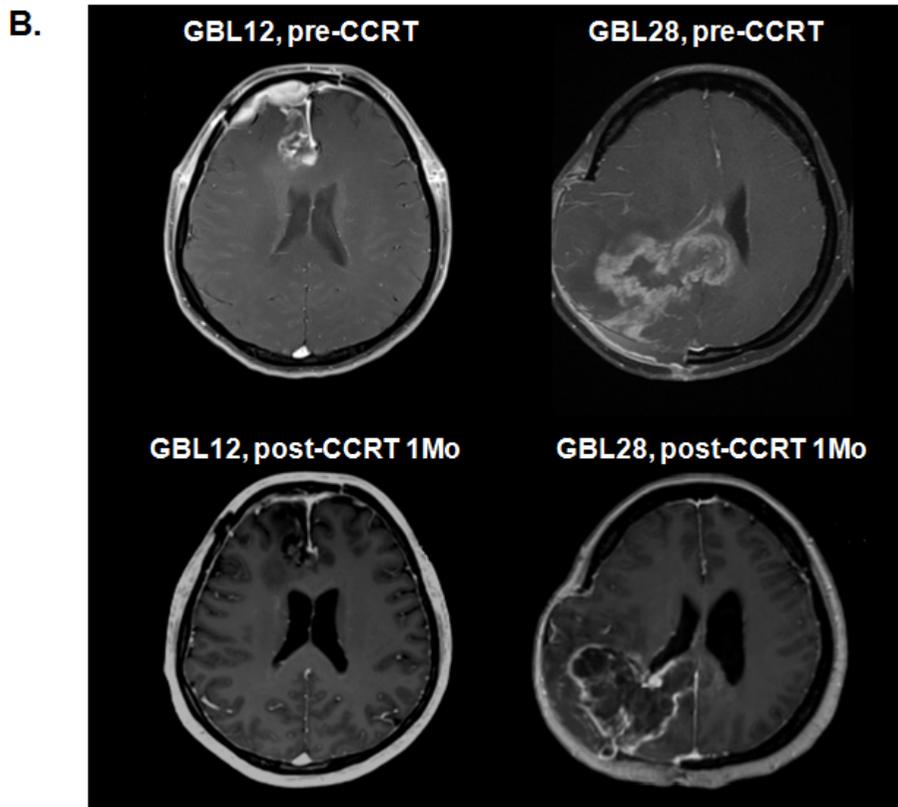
(B) MRI images of each cell line donors were taken before the start of concurrent chemoradiotherapy (CCRT) with TMZ, and after 1 month completion of CCRT.
